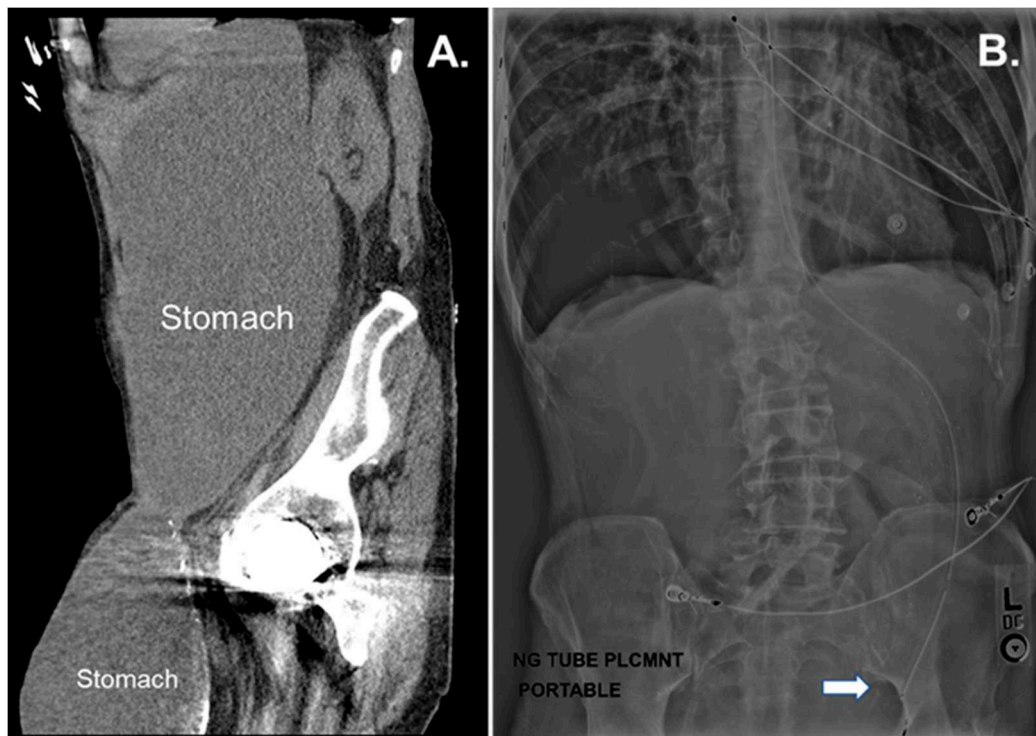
A, Sagittal computed tomography image of the abdomen depicting the stomach extending into the left groin causing gastric outlet obstruction. B, Coronal radiograph of the abdomen depicting the tip of the nasogastric tube in the left groin (arrow).
